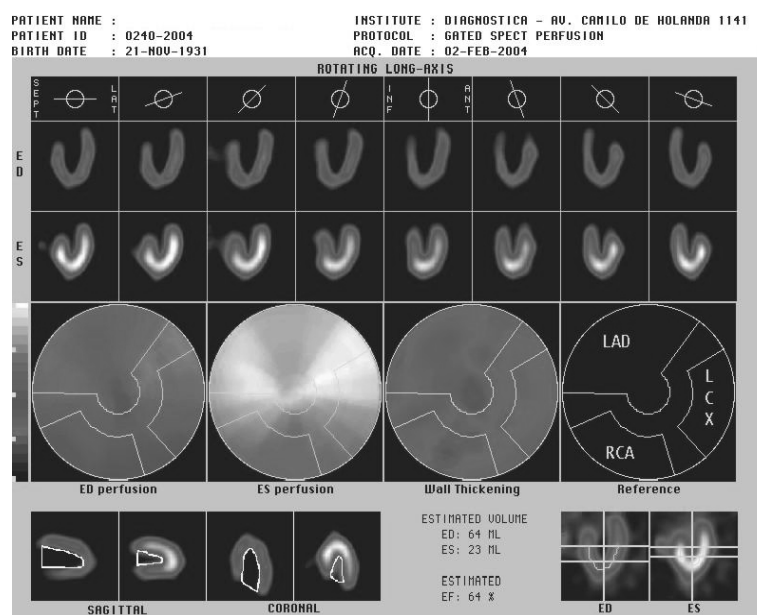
Images and parameters derived from the gated SPECT perfusion.
